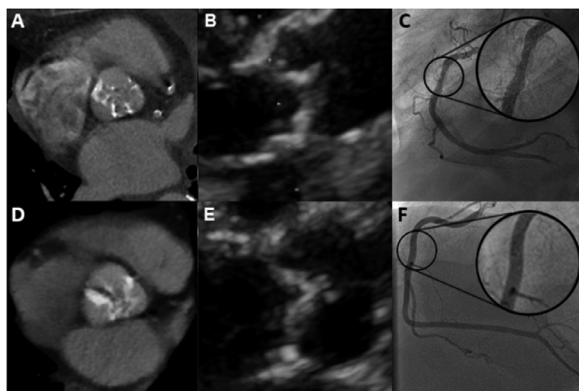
Representative MDCT (A), echocardiography (B), and coronary angiography (C) of a patient with severe aortic stenosis and concomitant coronary atherosclerosis. Representative MDCT (D), echocardiography (E), and coronary angiography (F) of a patient with severe aortic stenosis and normal coronary arteries. MDCT = multi-detector computed tomography.
